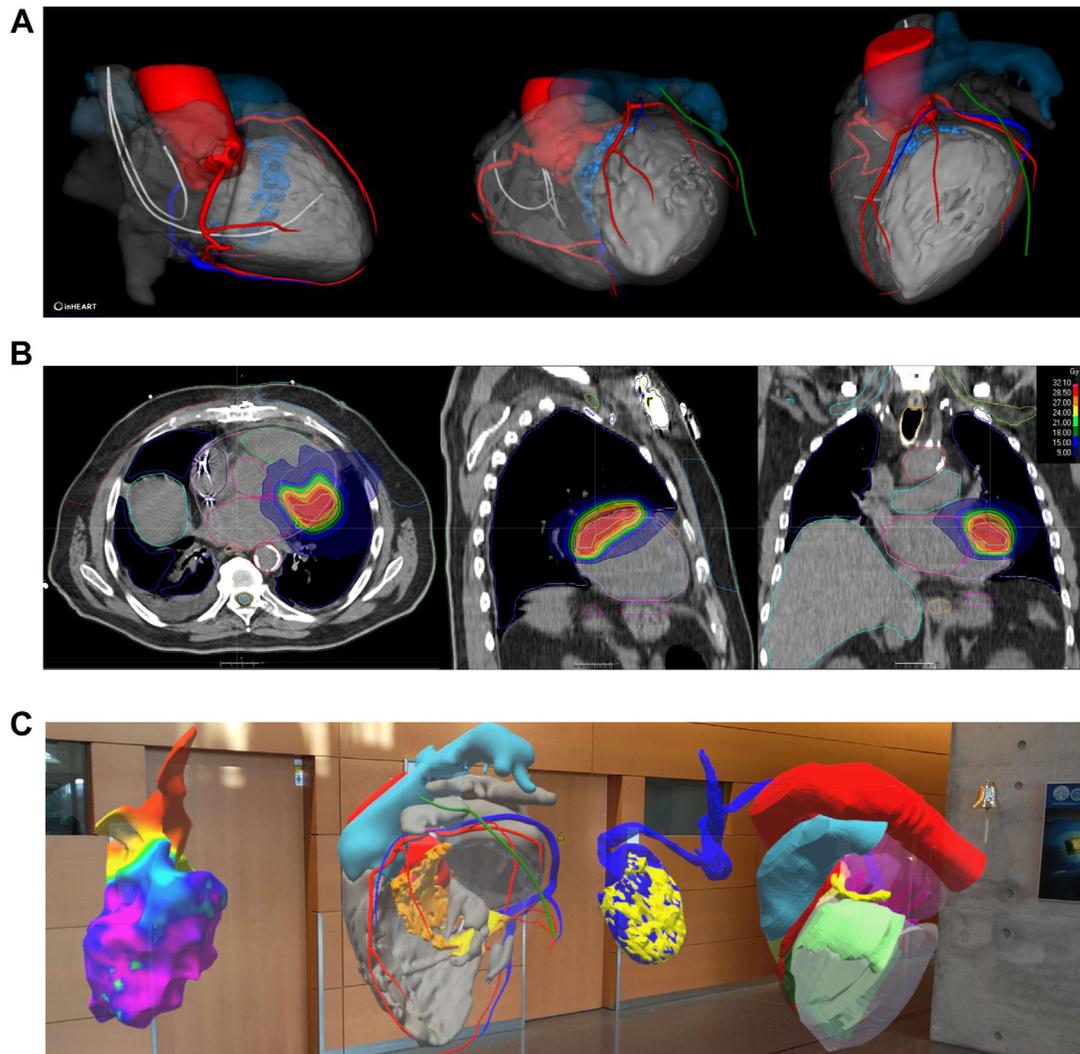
A: Segmented late iodine enhancement (LIE) computed tomography (CT) scan with intramural septal and anterior fibrosis (from left to right in right anterior oblique view, left anterior oblique view, and view to the left ventricular summit). Coronary arteries and aorta (red), coronary sinus (blue) implantable cardioverter-defibrillator (ICD) leads (white), LIE-defined fibrosis (light blue), and phrenic nerve (dark green) are depicted. B: Images from the final cardiac stereotactic body radiation therapy (cSBRT) plan from left to right in axial, sagittal, and frontal reconstruction, showing planning target volume in red and the corresponding dose distribution (24 Gy prescribed to the 80% isodose). C: Three-dimensional datasets visualized with mixed-reality device. Left: Electroanatomic bipolar endocardial map without visible scar. Middle: CT segmentation; intramural fibrosis for better visibility in orange. Right: Reconstructed cSBRT planning with target volume calculation (light green), left anterior descending artery and aorta (red), left circumflex artery (yellow), and ICD (blue/yellow).
